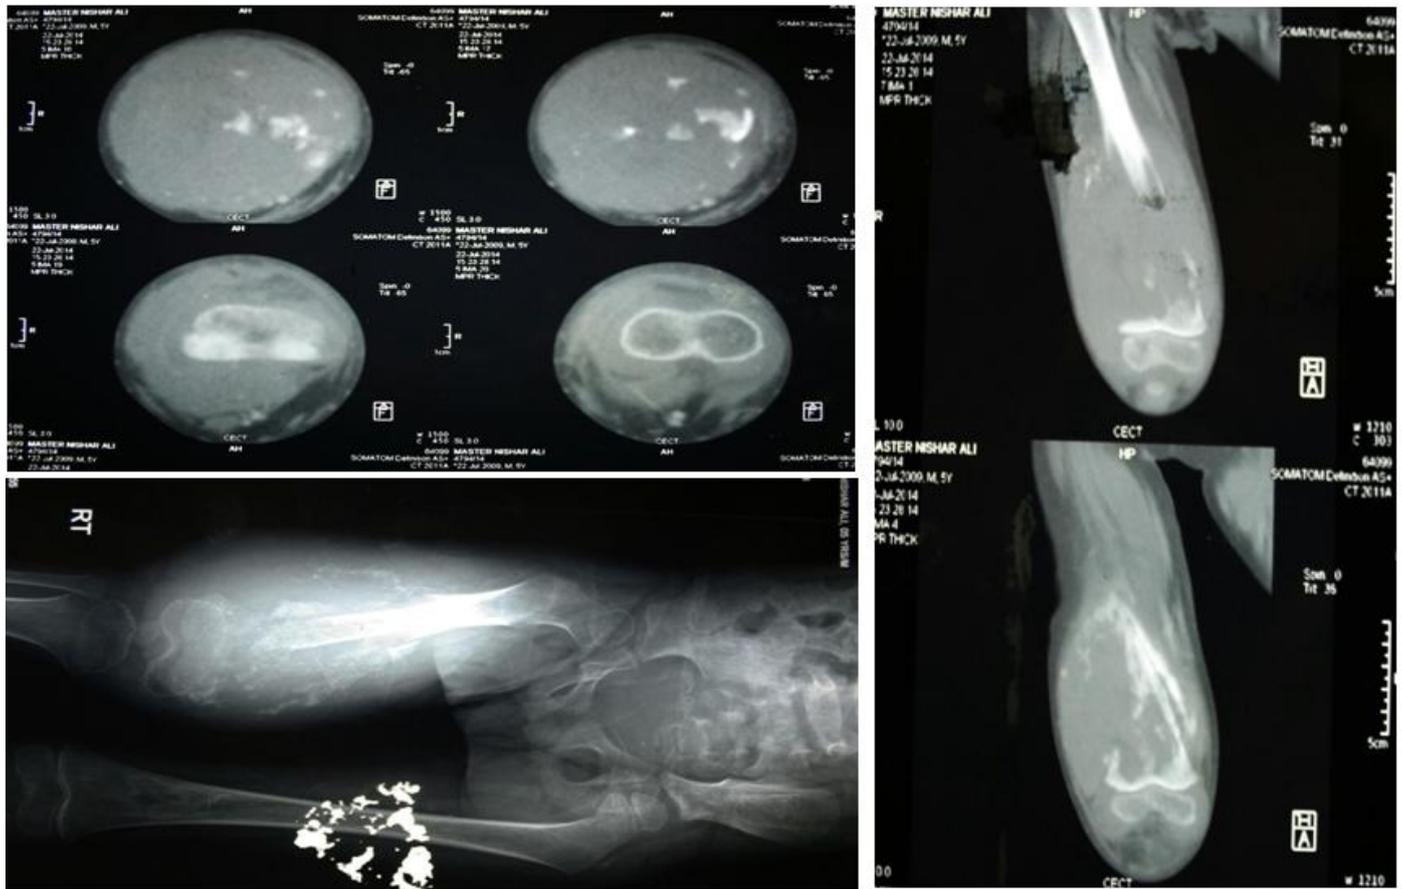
Coronal and axial CT sections of distal thigh showing large soft tissue mass with calcific foci involving muscles, marked erosion of shaft of femur with thick periosteal reaction
